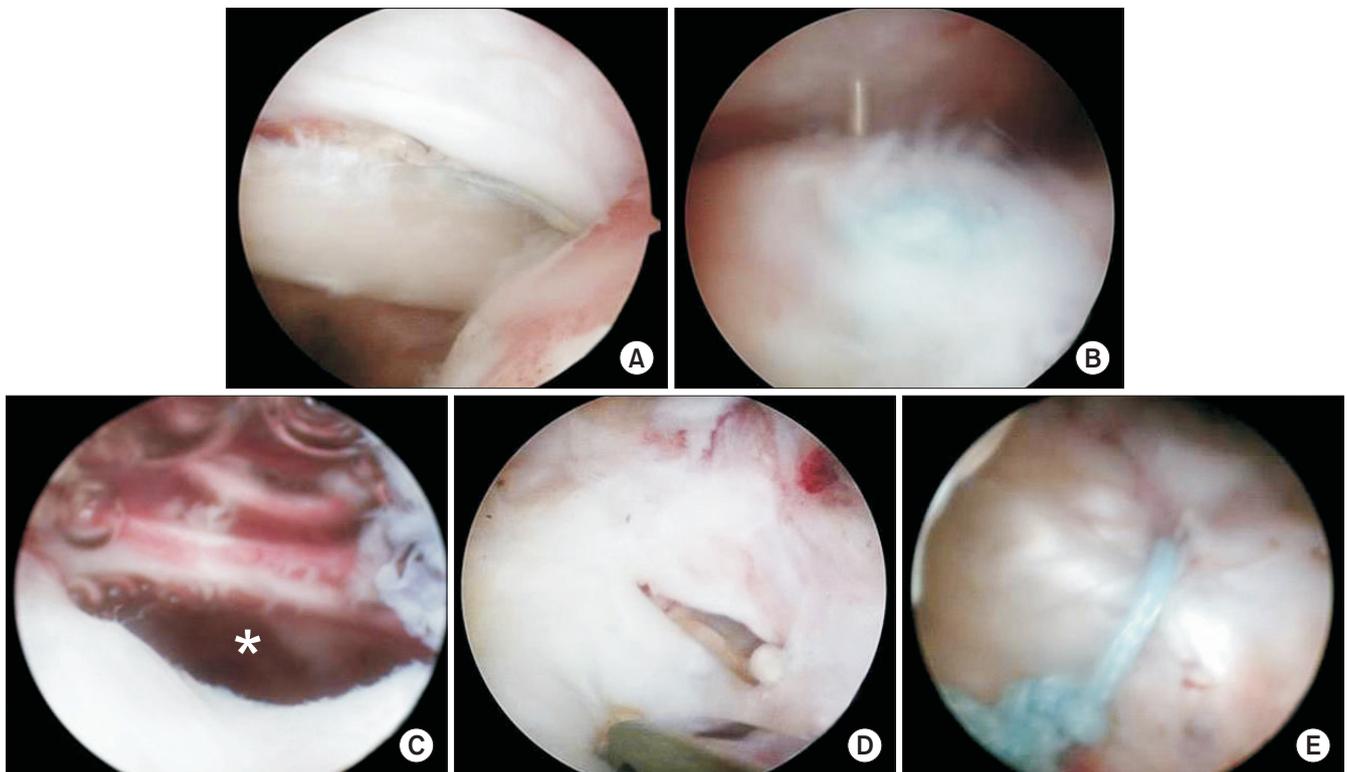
Arthroscopic images for the right shoulder. (A) The intraarticular side of the rotator cuff was healed up on the intraarticular view of the arthroscope through the posterior portal. (B) The bursal side of the rotator cuff was healed up on the subacromial view of the arthroscope through the posterolateral portal. (C) Large hole (asterisk) was seen at rotator interval which was mistaken for type 2 retear on magnetic resonance imaging. (D) The longitudinal splitting of the rotator cuff was noted and (E) repaired by the side-to-side technique with a nonabsorbable fiberwire (Ti-Con™).
